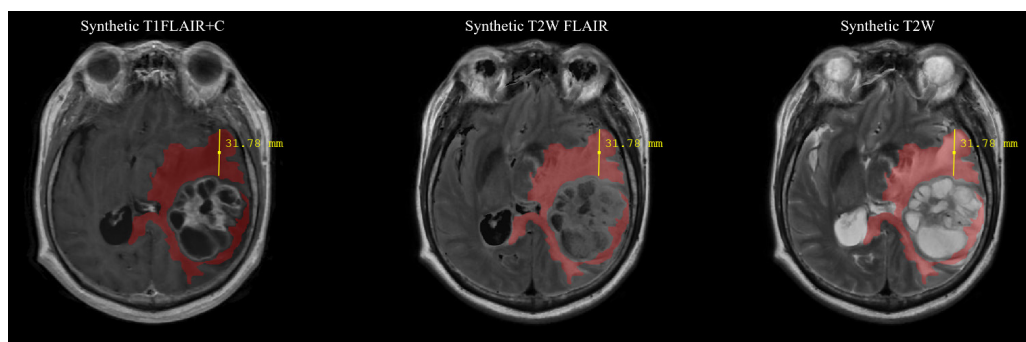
Representative image of edema degree. The red segmentation indicates the area of edema, while the yellow line represents the degree of edema (31.78 mm). T2W FLAIR, T2-weighted fluid-attenuated inversion-recovery; T1FLAIR+C, post-contrast T1 fluid-attenuated inversion-recovery; T2W, T2-weighted.
